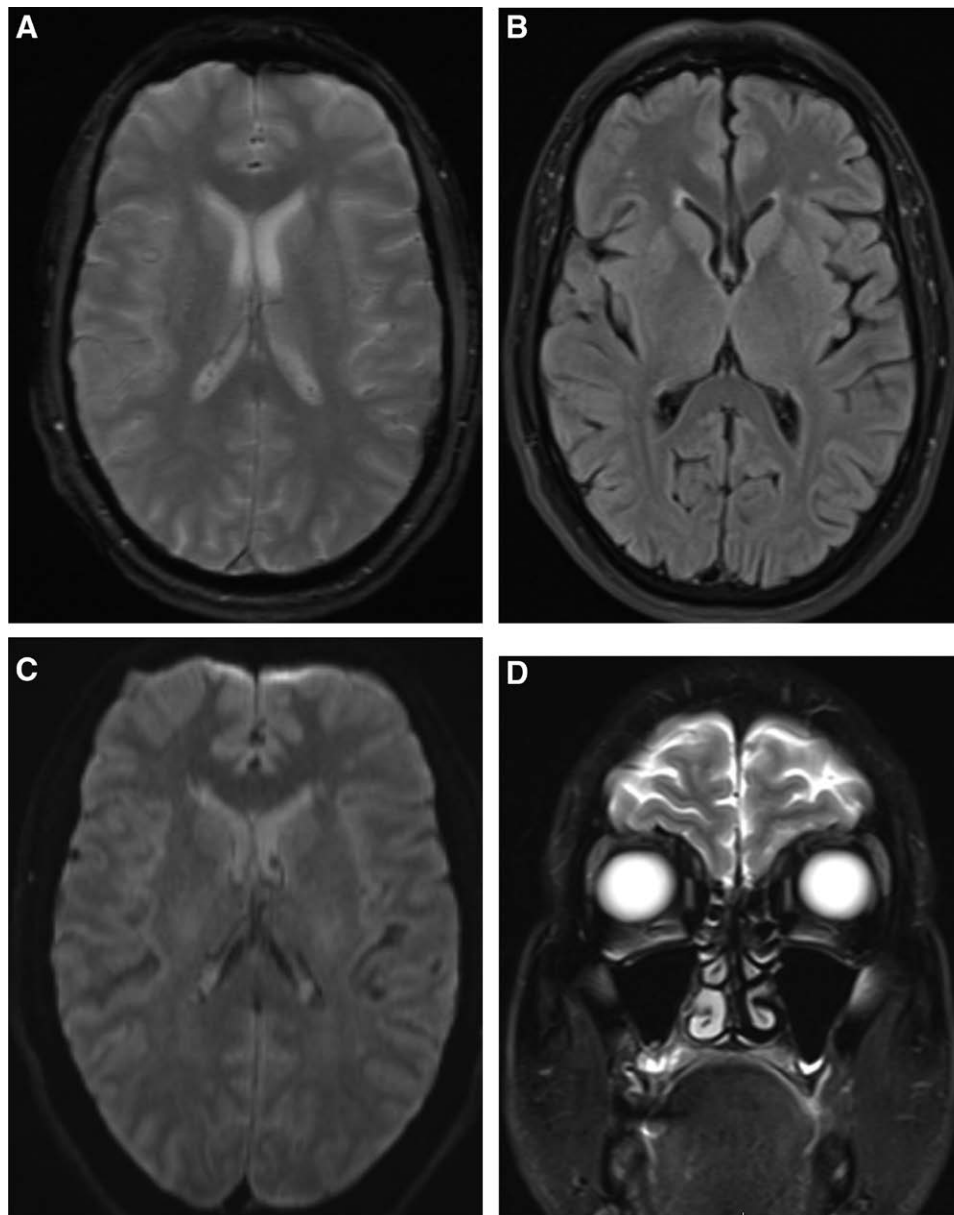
(A) MRI brain with different sequences (T2, flair, diffusion and coronal sequences) showed no cortical structural abnormalities, no vascular lesions in brain stem, no signs of increased intracerebral pressure, no mass lesions, no ocular muscles abnormalities, and no orbital masses. (B) MRI brain with different sequences (T2, flair, diffusion and coronal sequences) showed no cortical structural abnormalities, no vascular lesions in brain stem, no signs of increased intracerebral pressure, no mass lesions, no ocular muscles abnormalities, and no orbital masses. (C) MRI brain with different sequences (T2, flair, diffusion and coronal sequences) showed no cortical structural abnormalities, no vascular lesions in brain stem, no signs of increased intracerebral pressure, no mass lesions, no ocular muscles abnormalities, and no orbital masses. (D) MRI brain with different sequences (T2, flair, diffusion and coronal sequences) showed no cortical structural abnormalities, no vascular lesions in brain stem, no signs of increased intracerebral pressure, no mass lesions, no ocular muscles abnormalities, and no orbital masses. MRI = magnetic resonance imaging.
